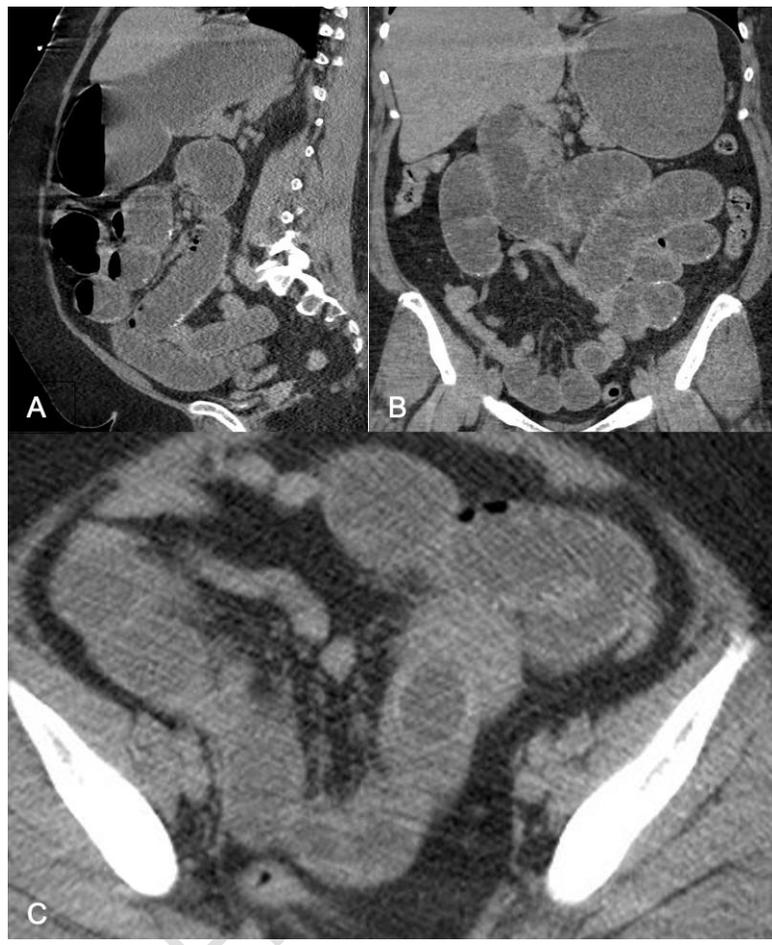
A: CT Sagittal view, multiple dilated loops of bowel and air fluid level. B: CT coronal view, C: CT, Axial view gallstone located in terminal ileum
